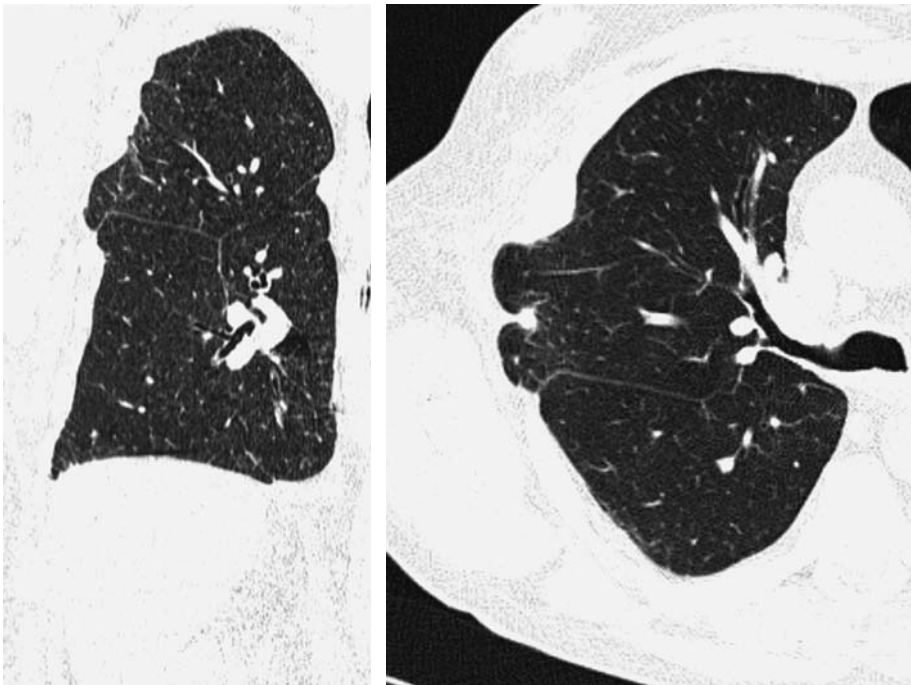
a Transverse CT section through right lung. CT section shows postoperative chest wall defect. b Coronal multiplanar reconstructed CT section through right lung. CT section shows postoperative chest wall defect
